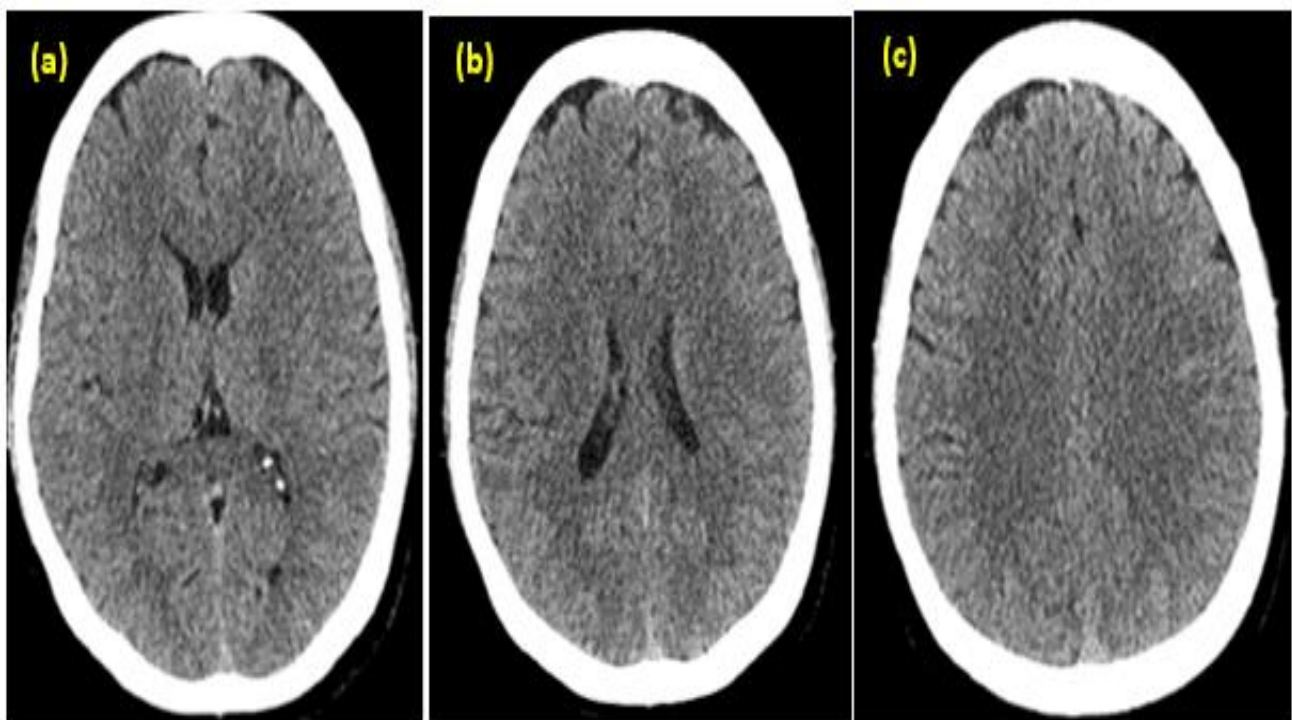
Non-contrast axial brain CT slices (a–c) showing no early ischemic changes (ASPECTS = 10)
